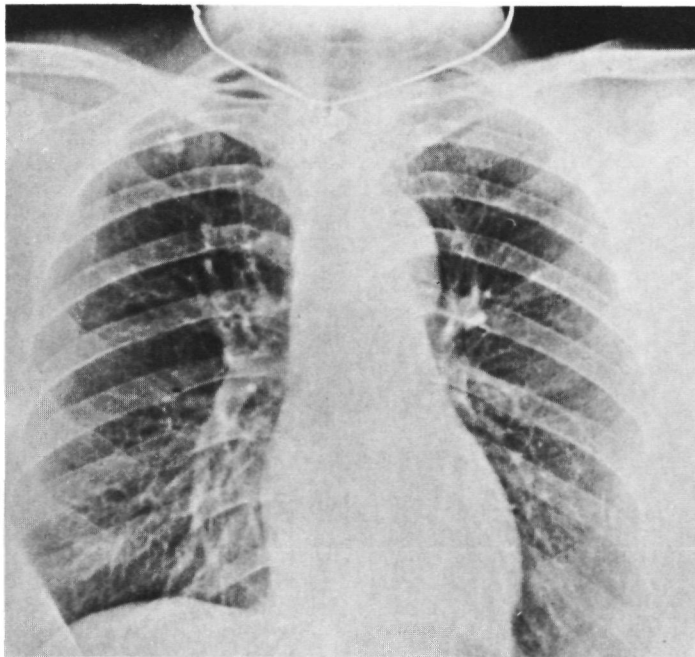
3 Male, 24 years, car-driver, patient 5 with CTAR. a. Chest X-ray at the time of detection of the CTAR, 6 years after trauma: mass lesion with calcified rim at the level of the aortic knob. b. and c. AP and lateral angiography: false aneurysm at the level of the aortic isthmus.
